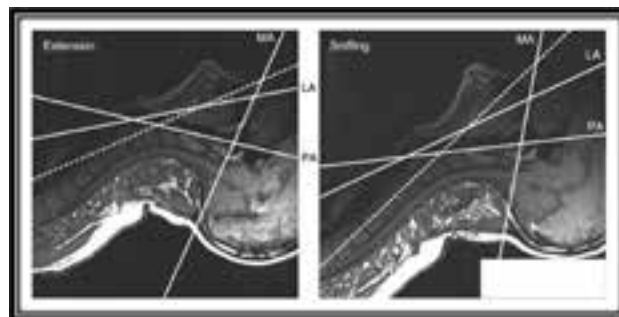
Pharyngeal (PA), laryngeal (LA) and mouth (MA) axes superimposed on MRI images (sagittal section) of head and neck region with head in extension and sniffing position. Dotted line—the line of vision.⁵
